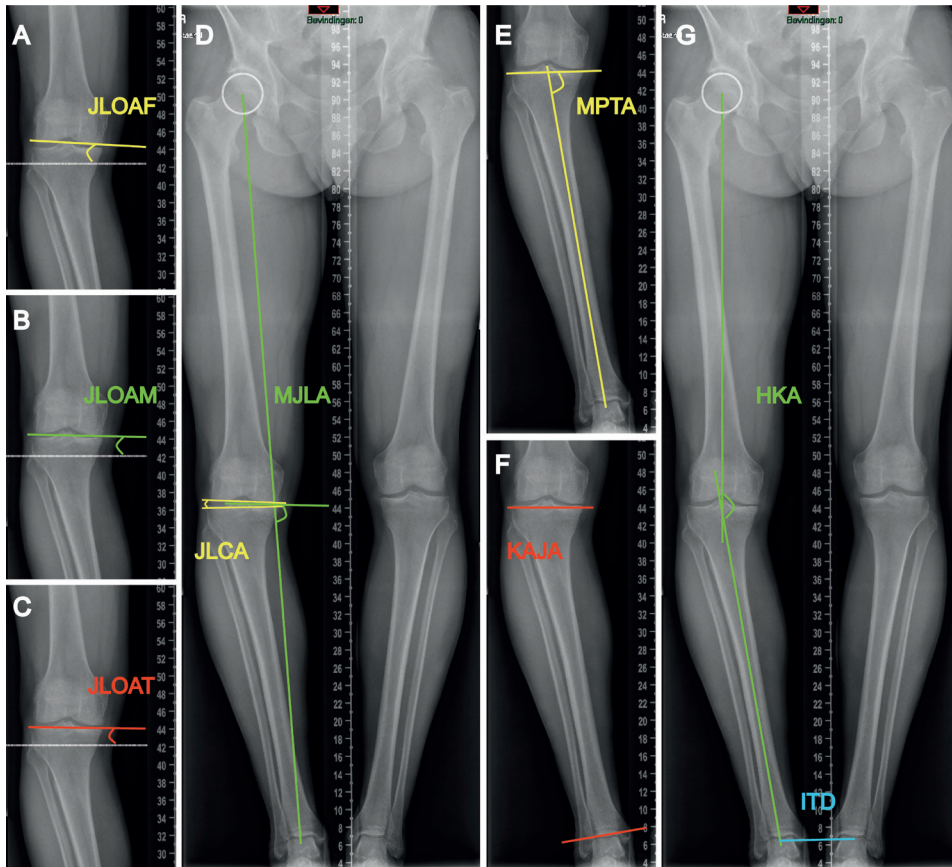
Measurements in anteroposterior long double-leg standing radiograph
